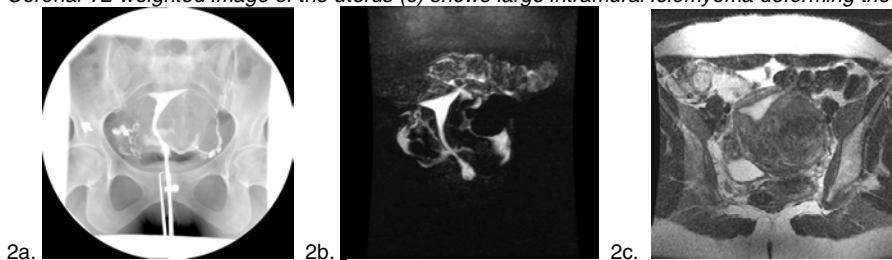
(a-c): Conventional HSG (a) and MR-HSG (b) both demonstrate free spill of contrast into the peritoneum and abnormal uterine contour. Coronal T2-weighted image of the uterus (c) shows large intramural leiomyoma deforming the uterine cavity.
